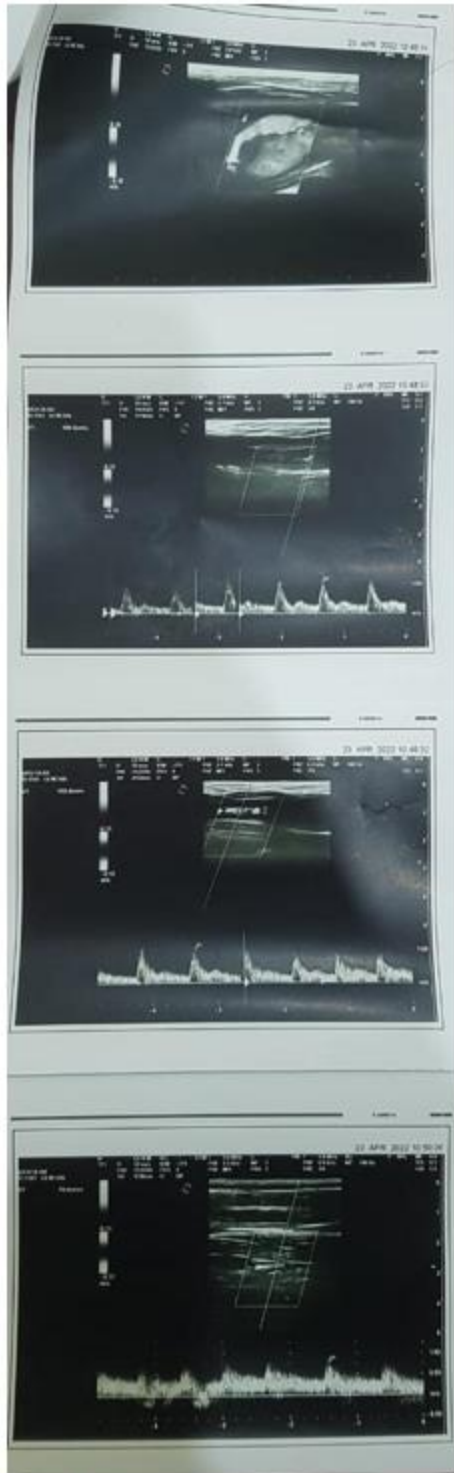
Doppler ultrasound
